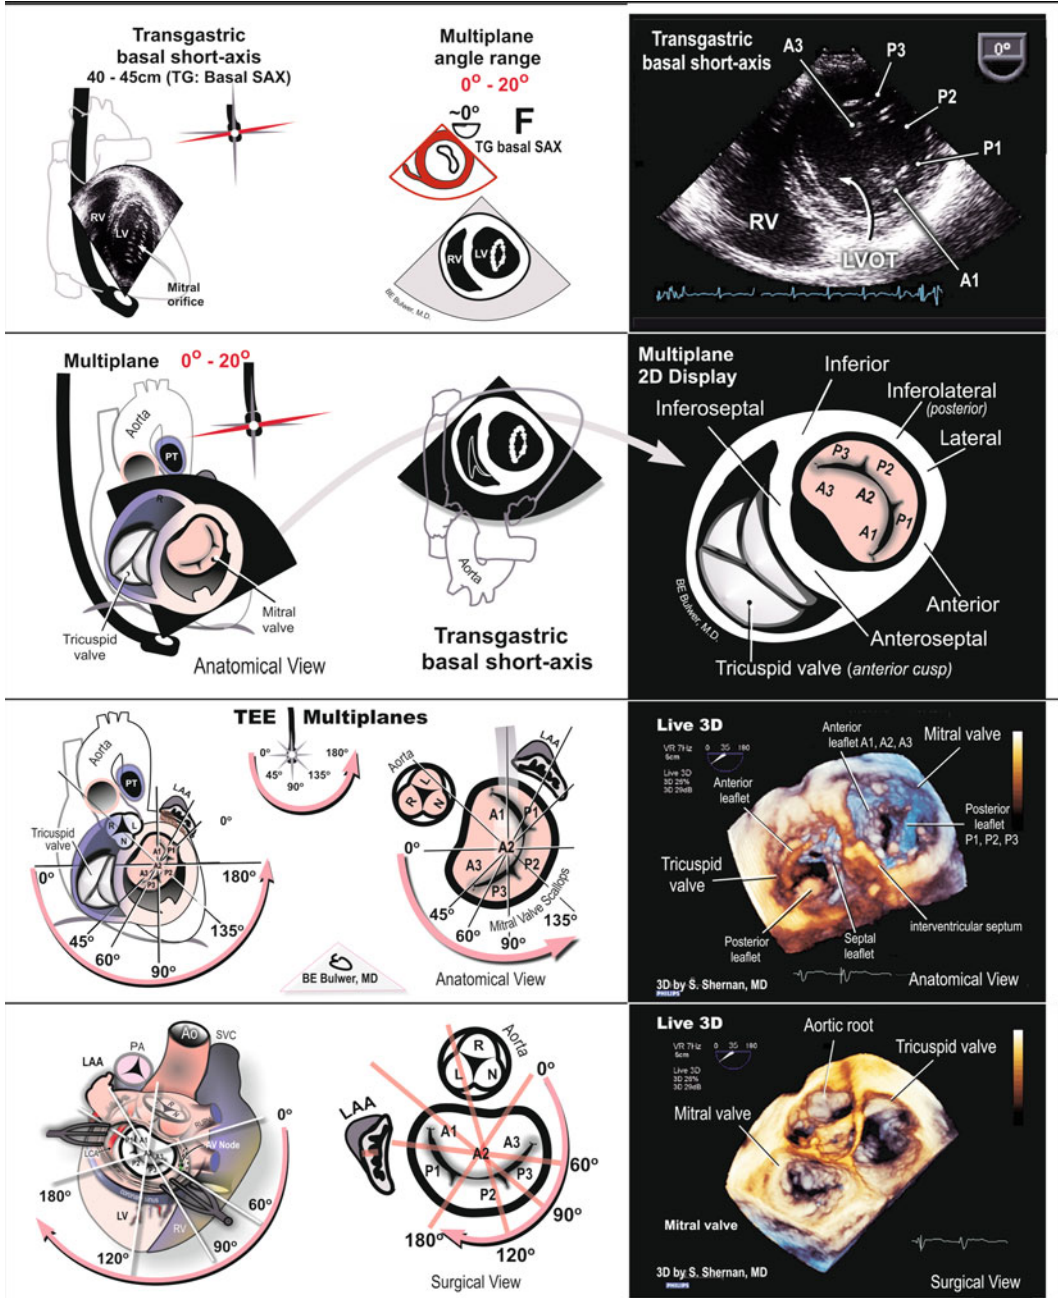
Transgastric Basal Short Axis View: Cross-Sectional Anatomy on 2D- and 3D-TEE Short-axis views of the mitral valve leaflets and scallops on transesophageal
